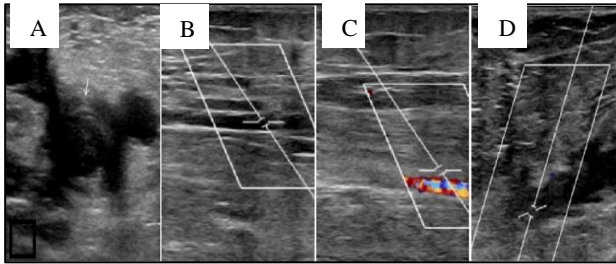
Right lower extremity ultrasound: A) thrombosis of right common femoral vein. B) thrombosis of the right superficial femoral vein. C) right profunda vein thrombosis. D) right popliteal vein thrombosis.
